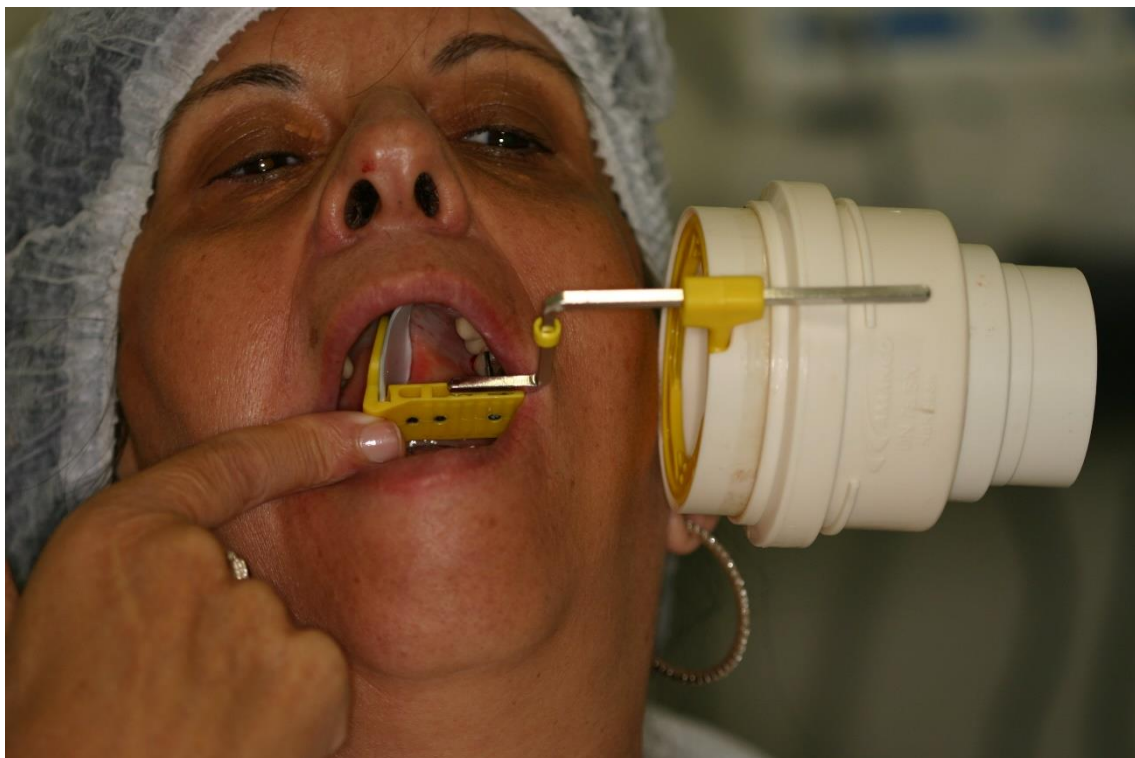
The personalized radiographic positioner and its modifications.
